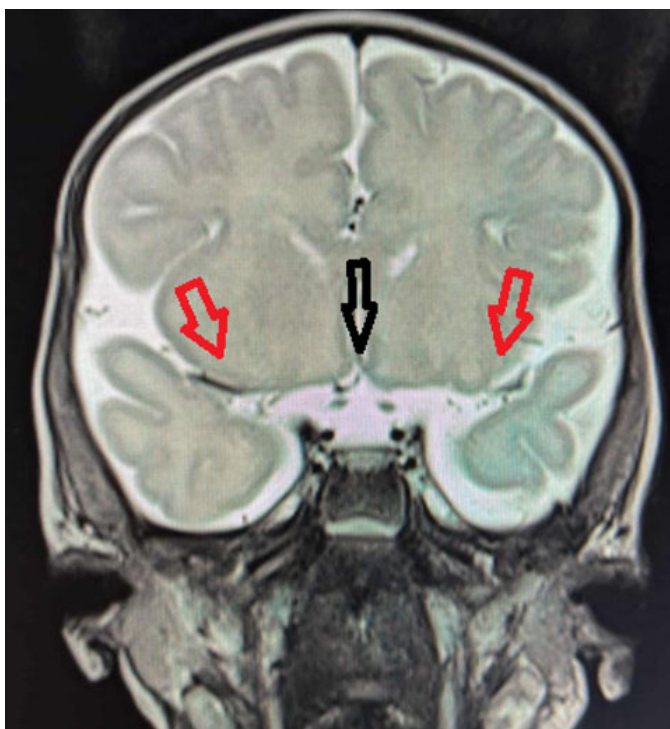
Coronal T2 MRI showing bilateral optic nerve hypoplasia (red arrows). The optic nerves appear markedly slender with small optic chiasm (black arrow).
